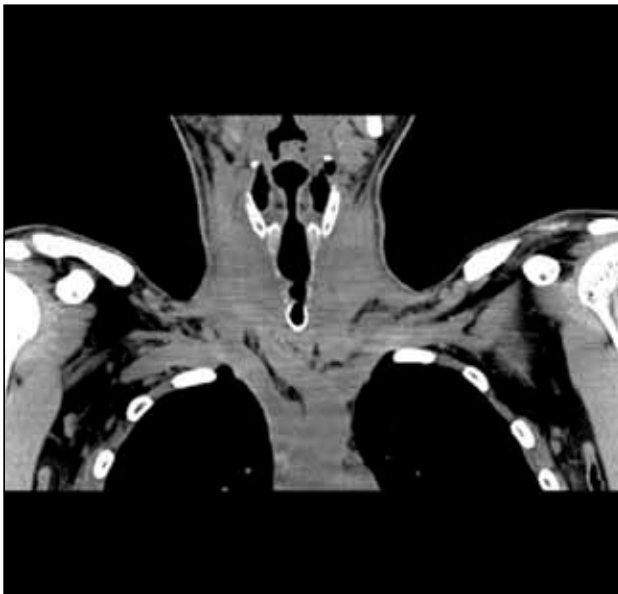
Cervical CT scan, coronal slice - heterogeneous, anfractuouse thyroid mass with central calcification
